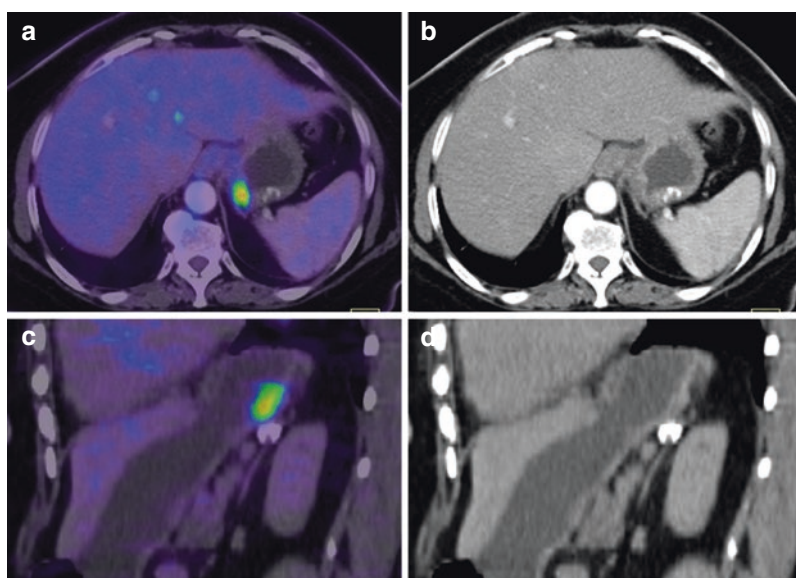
Incidentally detected FDG uptake in the posterior wall of cardia of the stomach (a - axial fused PET/CT, b - axial contrast enhanced CT, c - coronal fused PET/CT and d - coronal contrast enhanced CT sections). Upper GI endoscopy revealed a gastric ulcer, and biopsy was negative for malignancy
